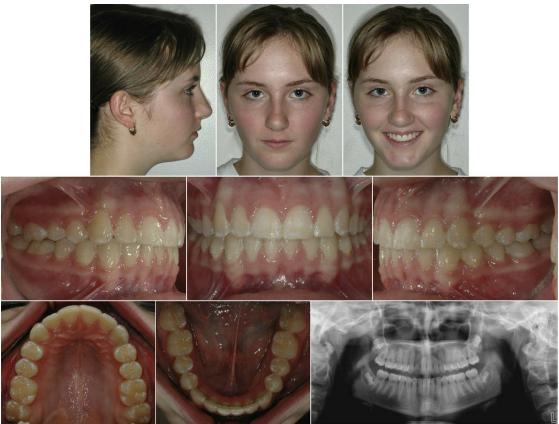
Postorthodontic intraoral/extraoral photographs and panoramic radiograph.
